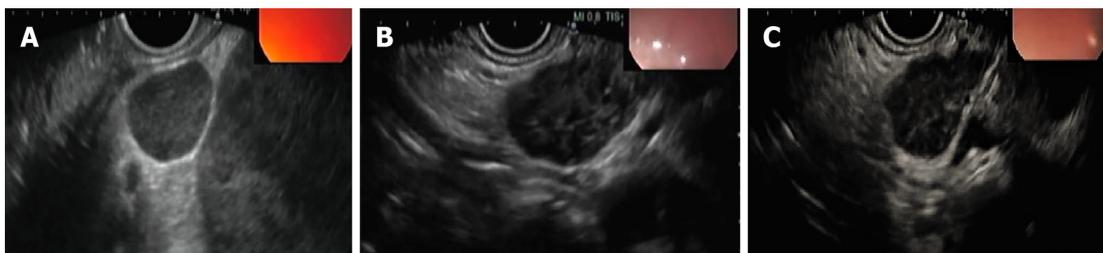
Endoscopic ultrasound. A: Hypoechoic node due to tuberculosis (TB) as seen on endoscopic ultrasound (EUS); B: Heteroechoic node due to TB as seen on EUS; C: Typical findings of TB lymphadenitis on EUS and fine needle aspiration cytology.
